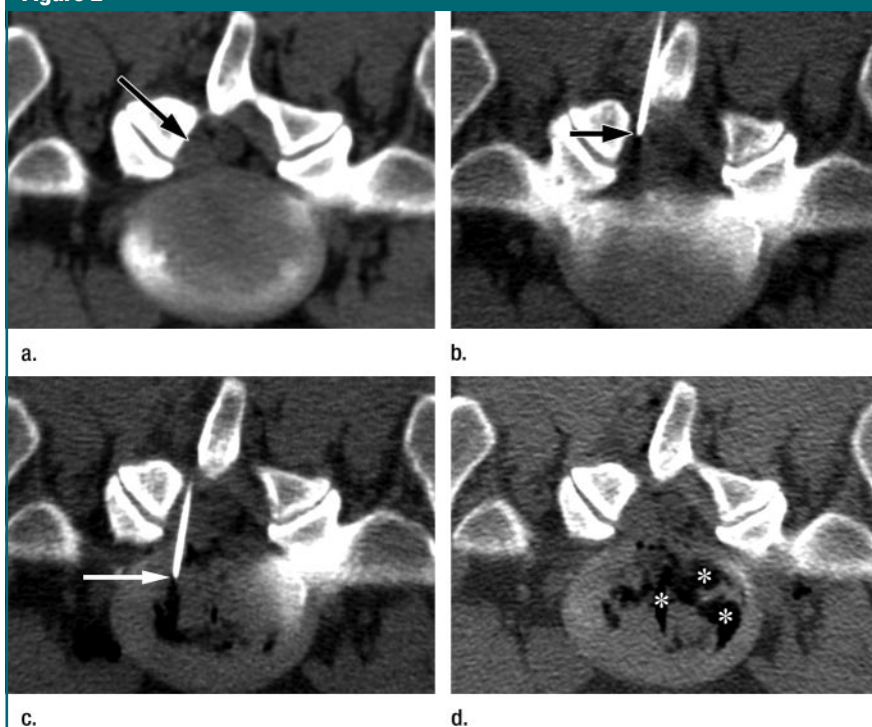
Transverse CT images of consecutive phases of O₂-O₃ chemodiscolysis with left interlaminar approach at L5-S1 level in 21-year-old man in prone position. (a) Preprocedural image shows right paracentral disk extrusion (arrow). (b) Tip of needle (arrow) is positioned close to the herniation; dural theca is not located along needle entry path. (c) Needle (arrow) is inside the disk and its position is extrathecal. After further needle entry, drugs are injected. (d) Postprocedural image shows wide distribution of gas (*) inside the disk.
